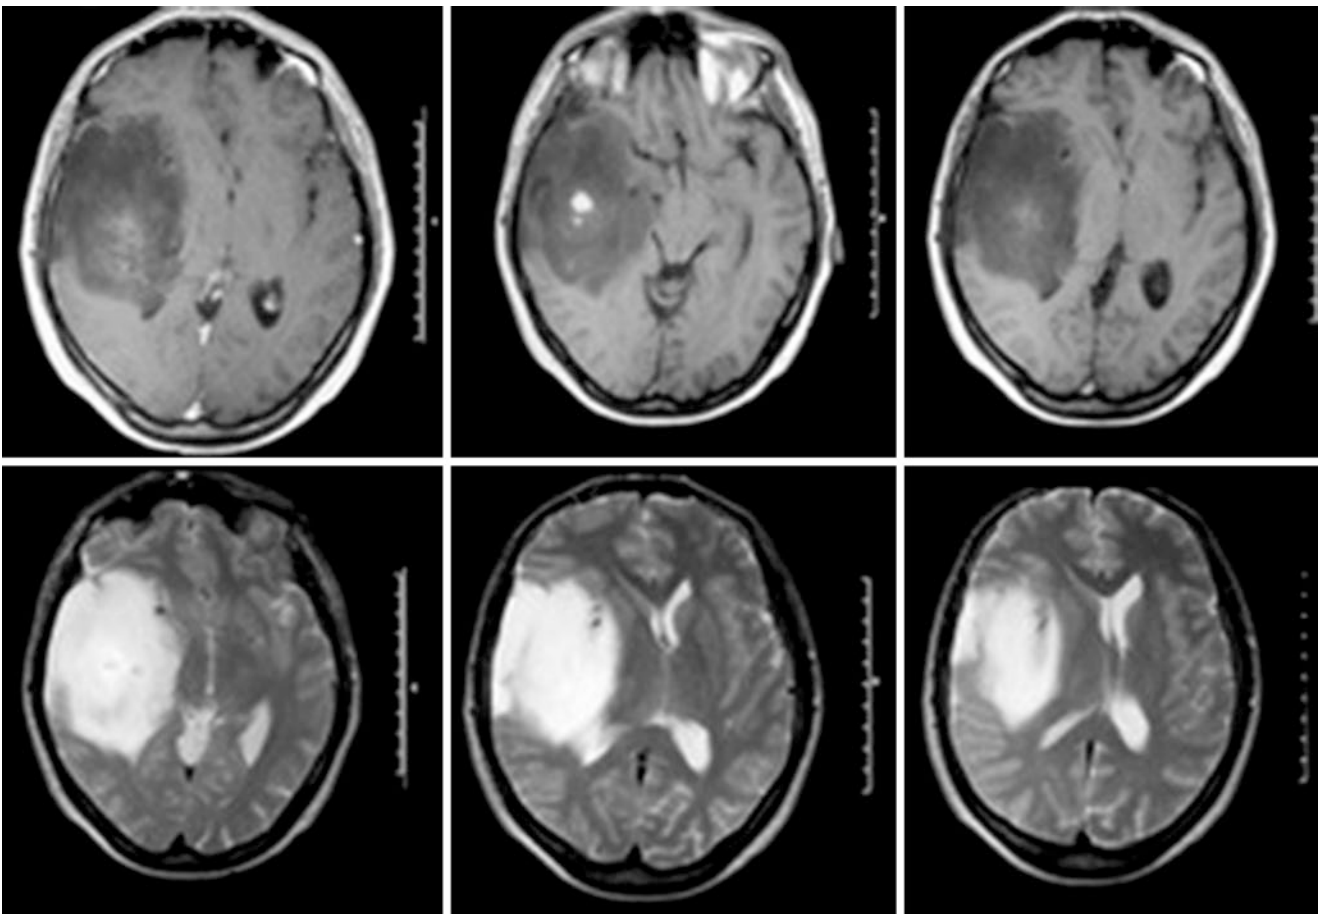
Axial MRI sections of a right insular glioma with temporal expansion and infiltration of the hippocampus (Yasargil type 5B)
